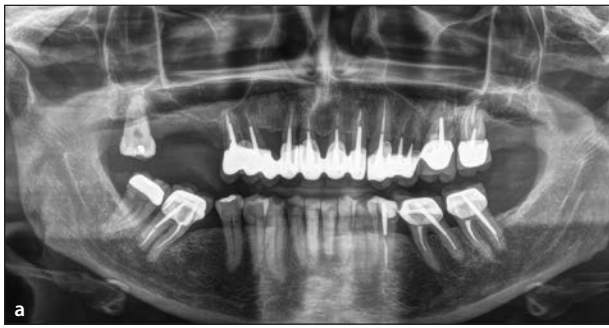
(a) Preoperative radiograph. (b) Five-year follow-up.
